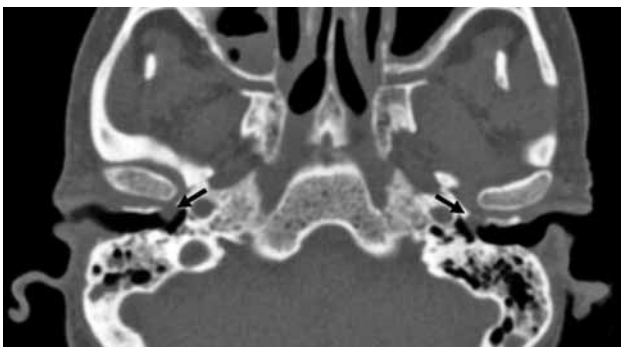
Computed tomography scan of a patient with both ears radiotherapy-related external auditory canal cholesteatoma. Radiotherapy-related external auditory canal cholesteatoma (right and left) with partial destruction of anterior-inferior bony canal.
